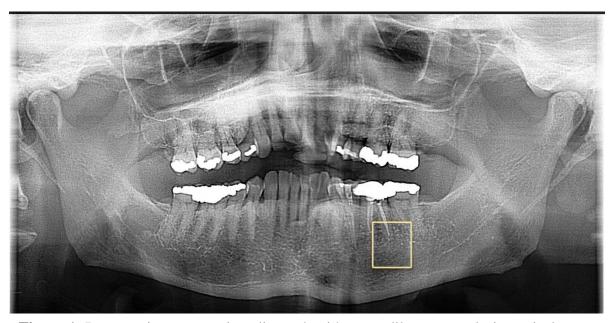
Preoperative panoramic radiograph with no readily apparent lesion apical to mandibular left first molar.
